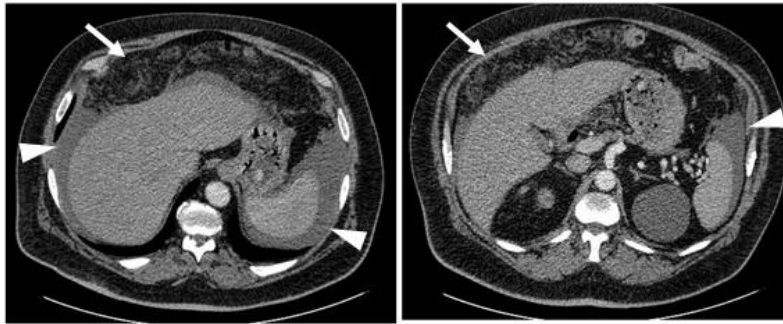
No-contrast enhanced CT-scan that shows peritoneal fat reticulation and micronodules, known as omental cake (arrow) and abdominal free liquid (arrowheads) suggesting peritoneal carcinomatosis
